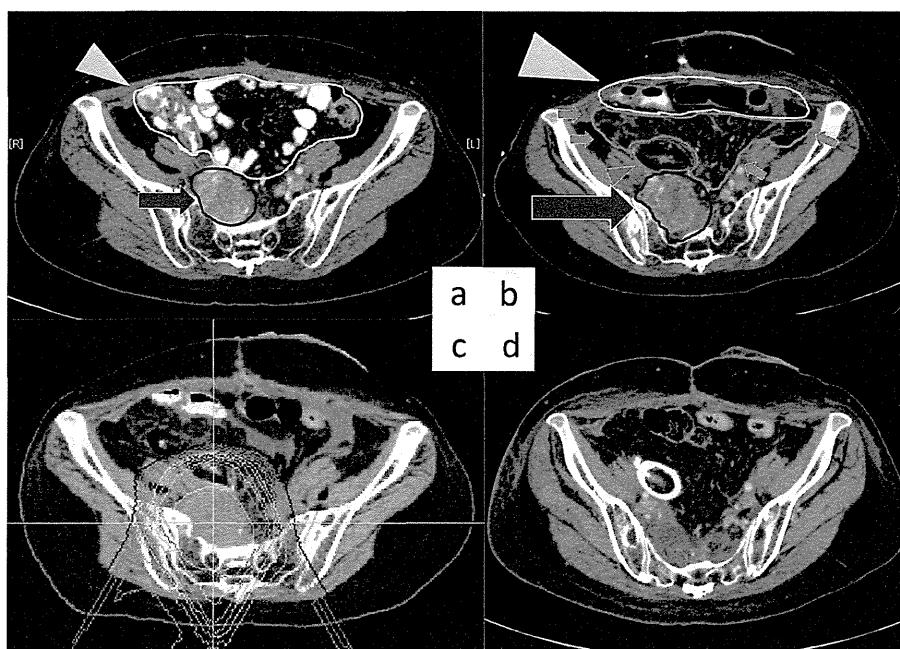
Abdominal CT before the operation shows the recurrent tumor (arrow) to be located very close to the gastrointestinal tract (arrow head).
